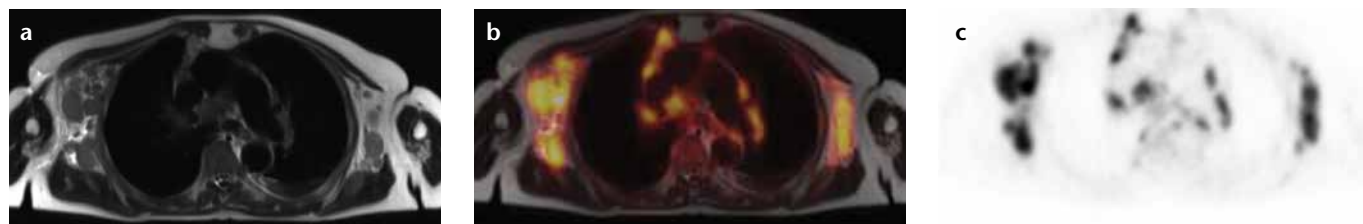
a–c. Simultaneous FDG-PET/MRI in a 72-year-old patient with an initial diagnosis of highly malignant B-cell type non-Hodgkin lymphoma. The anatomical dataset shows multiple enlarged axillary, mediastinal, as well as hilar lymph nodes (a, T2-weighted HASTE) with elevated FDG-uptake in PET (b, fusion; c, FDG-PET).
